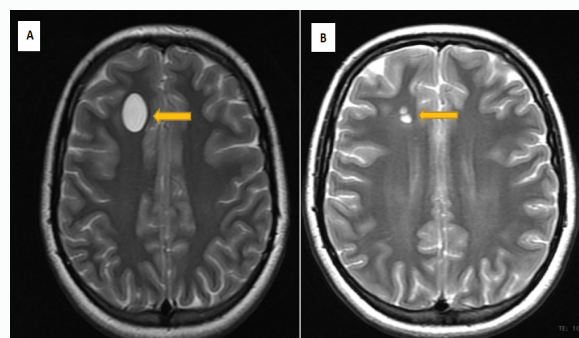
A: Pre-operative MRI scans of a 16 year old female who presented with epileptic seizures, yellow arrow showing the cystic lesion in the right cerebral hemisphere. B: Postoperative MRI scan, yellow arrow showing the aspirated lesion.
